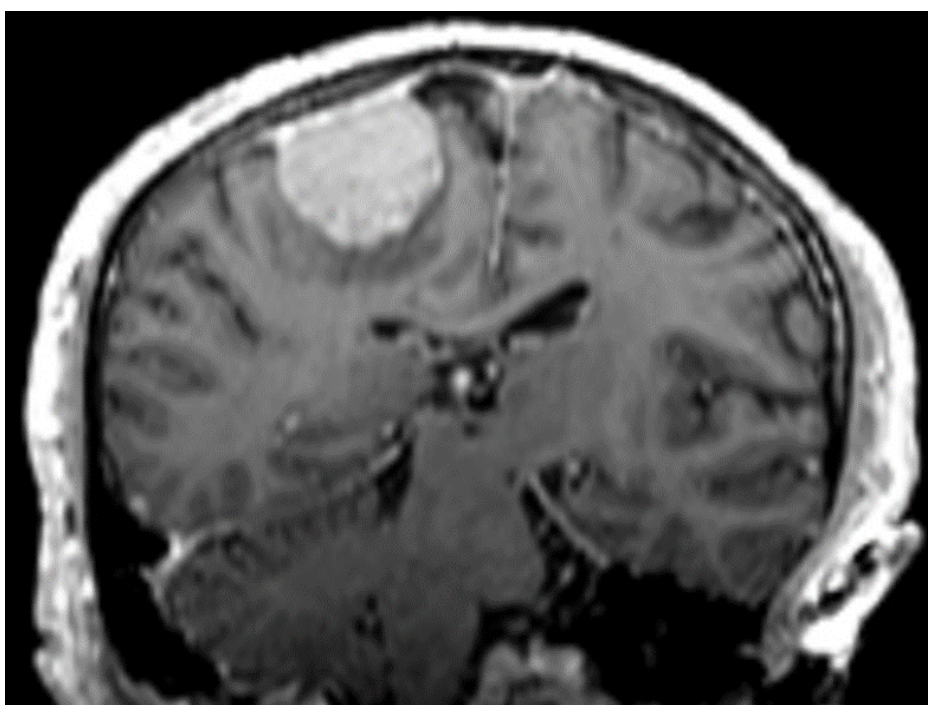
Corresponding coronal MR image of the same patient with atypical meningioma
